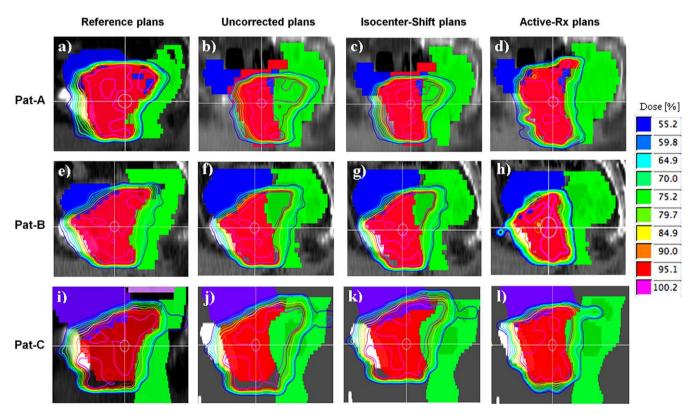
(a), (e), (i): Reference plans calculated on the CT with empty rectum, (b), (f), (j): dose distributions without a position correction (uncorrected plans) calculated on the CT with distended rectum, (c), (g), (k): dose distributions with isocenter correction (Isocenter-Shift plans) based on the CT with distended rectum, (d), (h), (l): dose distributions of re-optimized plans (Active-Rx plans) based on the CT with distended rectum. For patient-C the dose distributions in (j), (k) and (l) were calculated on a modified CBCT.
